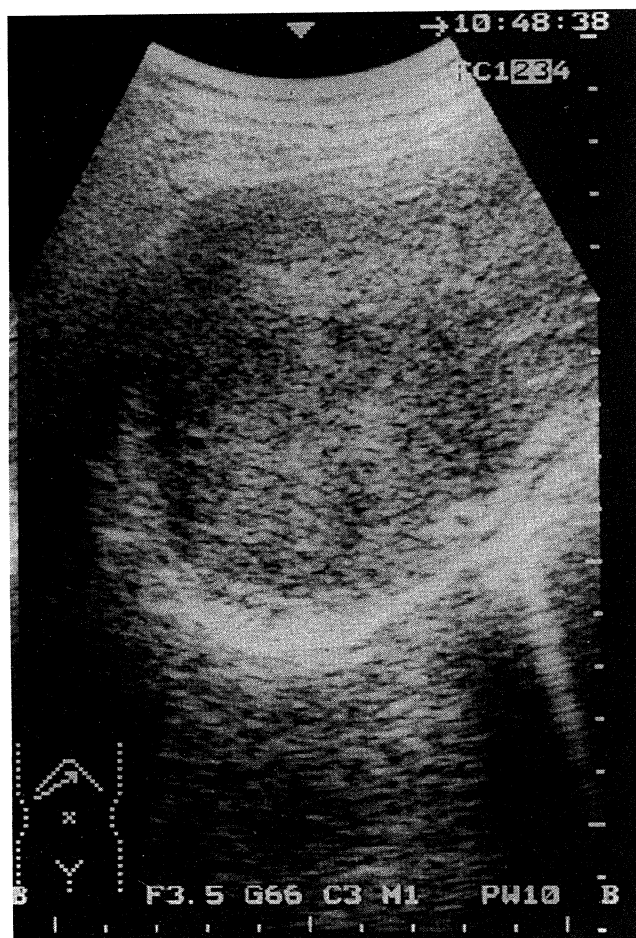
Ultrasonographic findings for case 1
